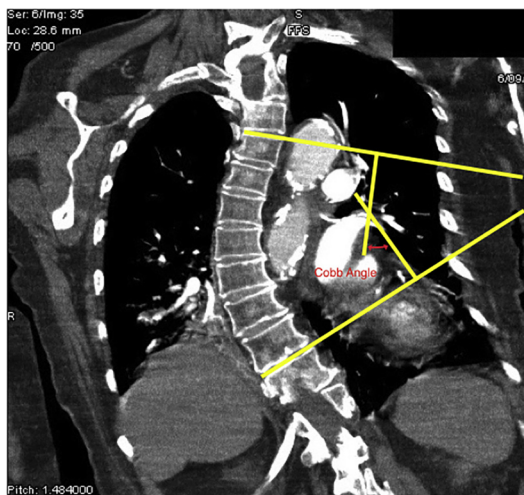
Chest computed tomography scan (coronal view) of a patient with kyphoscoliosis. The angle formed from the 2 yellow lines drawn parallel to the vertebrae of the scoliotic curve is the Cobb angle.
